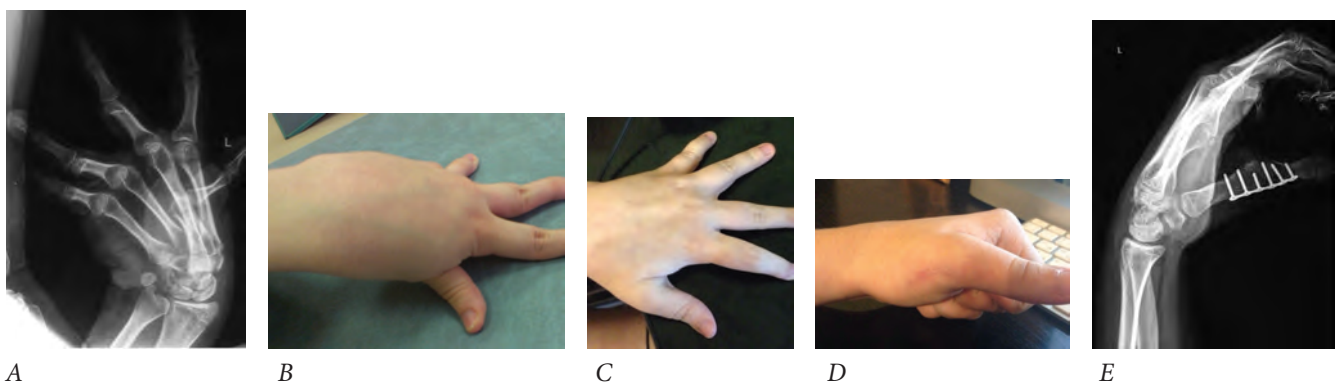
Patient O., 17 years old. A: Frontal projection of an X-ray image of the patient's hand. Dislocation of the metacarpophalangeal joint, adduction of the first metacarpal bone. B: Position of the patient's hand before surgery. C and D: Position of the patient's hand 10 months after surgery. E: Lateral projection of the X-ray image of the patient's hand after surgery
